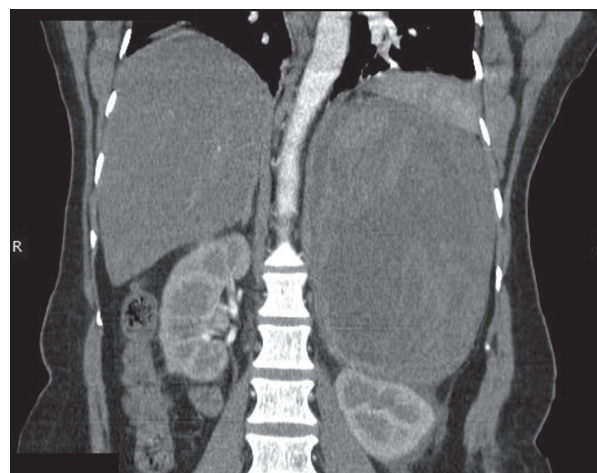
Coronal contrast-enhanced computed tomography (CECT) image of left adrenal tumor
